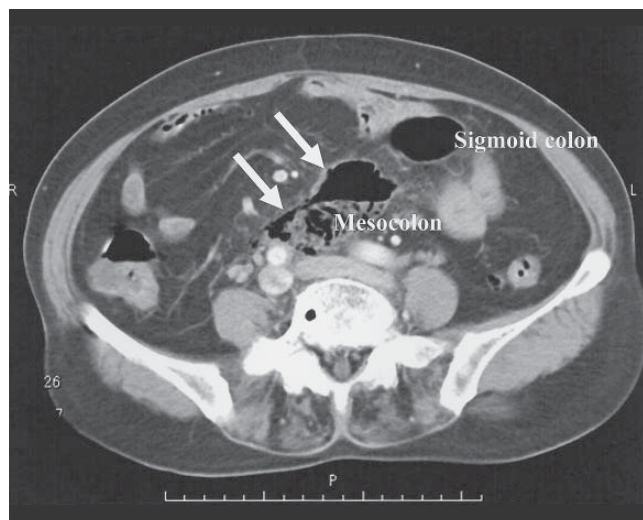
CT revealed ill-defined air collection in the middle of the anterior pararenal space (arrow).
